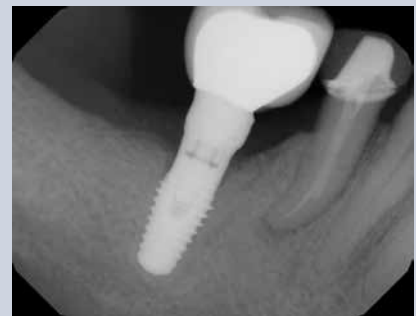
Six month post-operative radiograph with reattachment of the original crown. Partial bone regeneration of the lesion is demonstrated.
